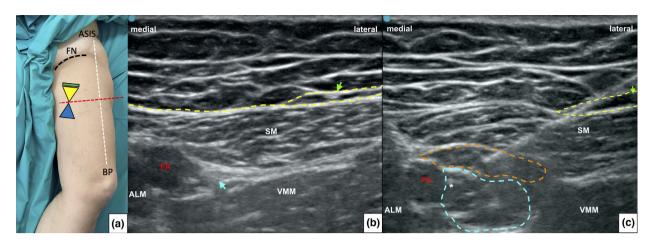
The para-sartorial compartments (PASC) block. (a) The ultrasound probe is first placed on the medial aspect of the thigh, at the level of the midpoint (red dashed line) between the base of the patella (BP) and the anterior superior iliac spine (ASIS). This point usually coincides with the distal end of the femoral triangle (yellow triangle) and the beginning of the adductor canal (blue triangle). The ultrasound probe is moved cranially until the intermediate femoral cutaneous nerve is visualised above the sartorius muscle (SM). The green rectangle represents the ideal probe position. The black dashed line (FN) indicates the femoral crease, where the femoral nerve is traditionally blocked. (b) Ultrasound view of intermediate femoral cutaneous nerve (green arrow) at the level of proximal femoral triangle (blue arrow), above the SM, vastus medialis muscle (VMM) and adductor longus muscle (ALM). (c) The needle tip (white asterisk) is placed inside the femoral triangle and first injection is performed, producing spread within the intracanalar compartment (blue dashed line). Subsequently, the needle is withdrawn, and local anaesthetic injected into the subsartorial compartment (orange dashed line). Finally, the needle is withdrawn again to perform the last injection in the suprasartorial compartment (yellow dashed line) to block the intermediate femoral cutaneous nerve
